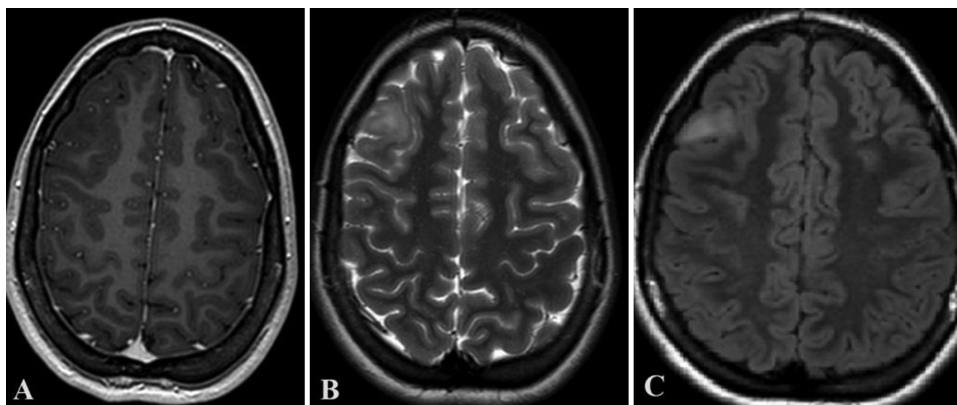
Follow-up axial T1-weighted (A), T2-weighted (B), and FLAIR (C) MR images demonstrating interval development of the previous T2-FLAIR hyperintense lesion in the right middle frontal gyrus.
